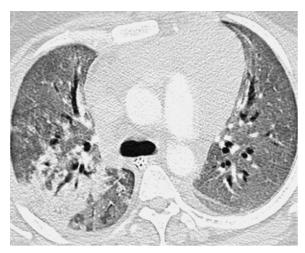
PERDS in a 30-year-old man 9 days after autologous HSCT for Hodgkin lymphoma. Axial HRCT image shows diffuse bilateral ground-glass opacities and peribronchial consolidation in the right upper lobe. The pulmonary arteries are not enlarged, a finding that helps distinguish engraftment syndrome from pulmonary edema.
